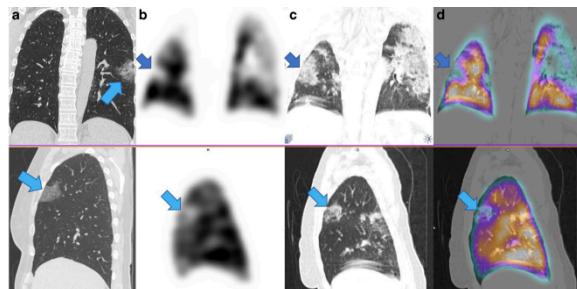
a. typical mild ground-glass infiltration on an unenhanced CT scan
